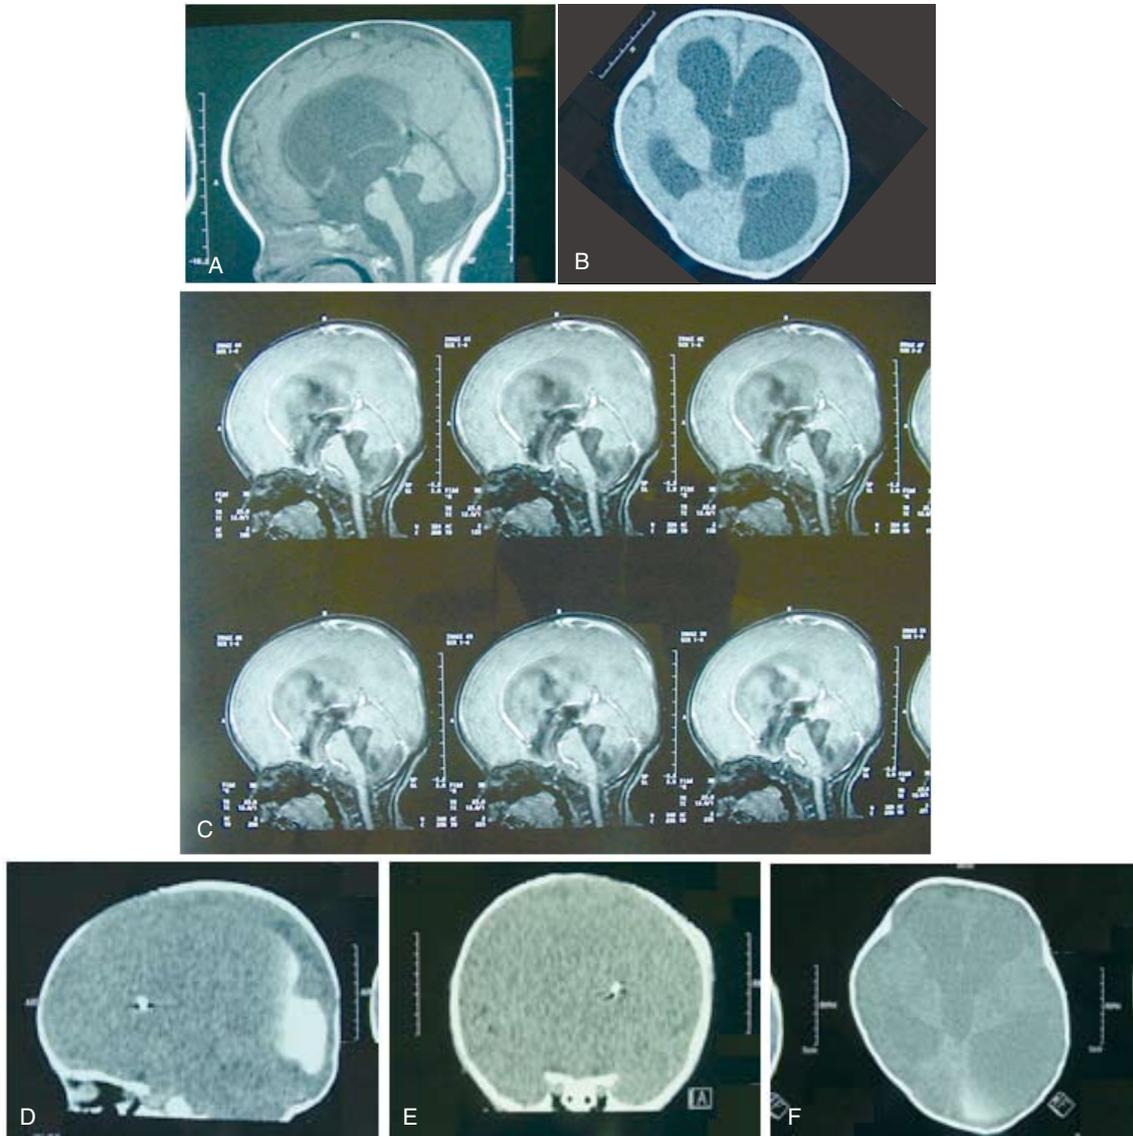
A, B, C: The physical examination revealed cleft lip/plate and monoventricle with a dorsal sac on MR imaging, T2-weighted image. D: The Cine-mode MR image. E, F, G: The Ventriculocisternography performed via Ommaya reservoir (immediately after contrast injection [E], and 6 hours injection [F]) revealed patient aqueduct and isolated dorsal sac from the major CSF pathway. Furthermore, significant CSF flow in the trans-ependymal-interstitial brain parenchymal route, so called the “Minor” CSF “Minor” pathway (E, F, G).
